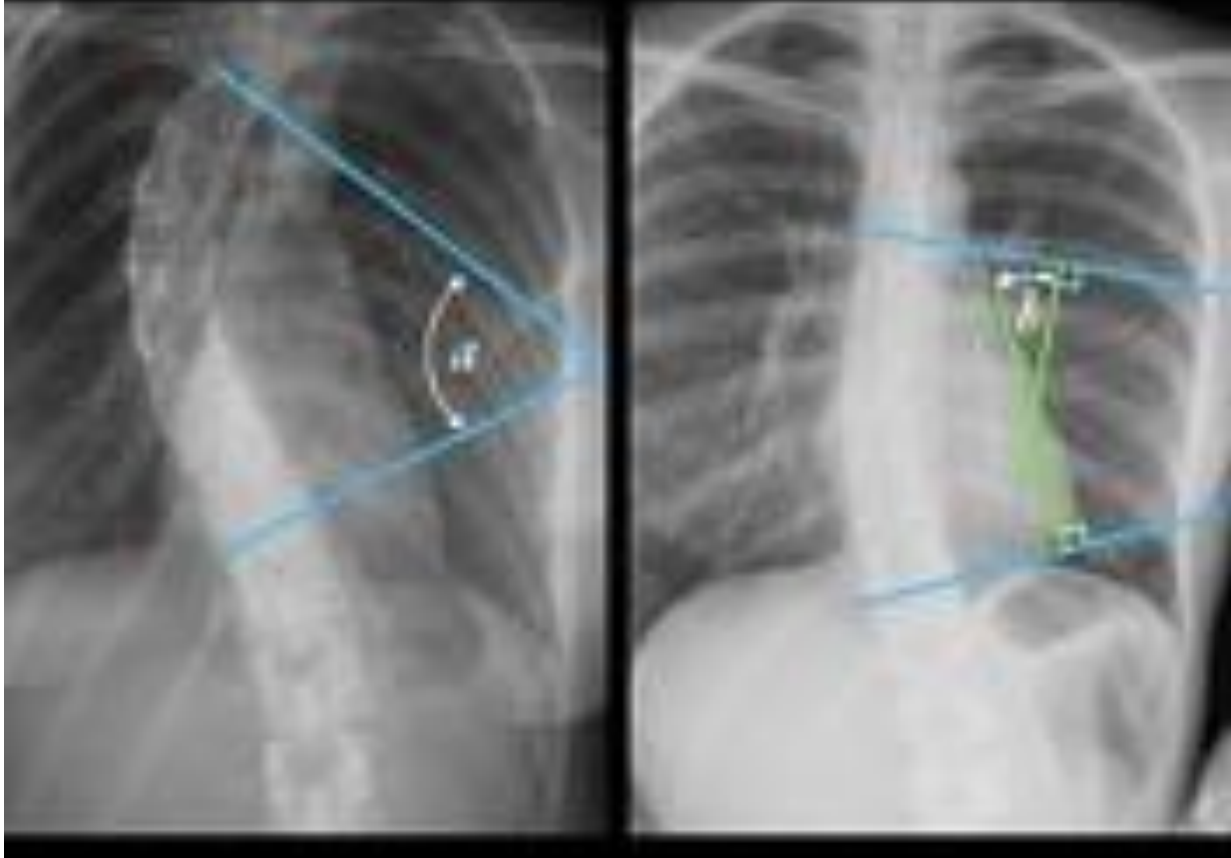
Cobb angle measurement from radiographic images
